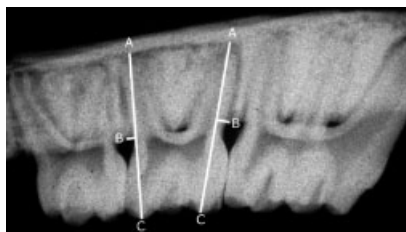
Digitized X-ray of the left maxilla. AB indicates the distance from apex (A) to intersection (B) and AC the distance from apex (A) to cusp tip (C).
